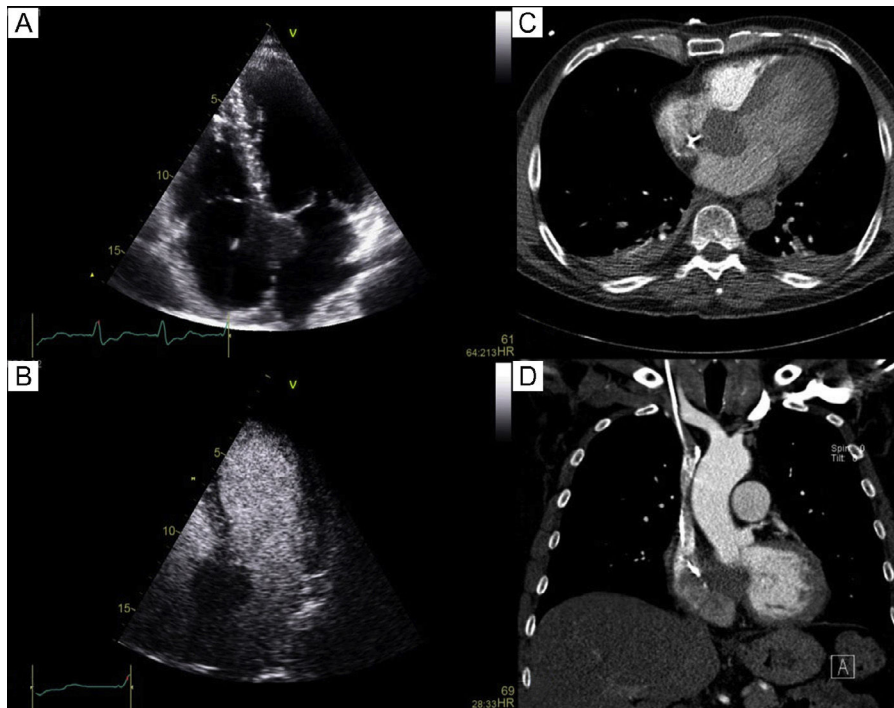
A: transthoracic echocardiography revealing the nodular mass in the interatrial septum, near the mitral and tricuspid valves, without opacification after ultrasonographic contrast administration (B). C, D: computed tomography displayed the 36 × 37 mm mass with a density similar to that of the interventricular septum.
